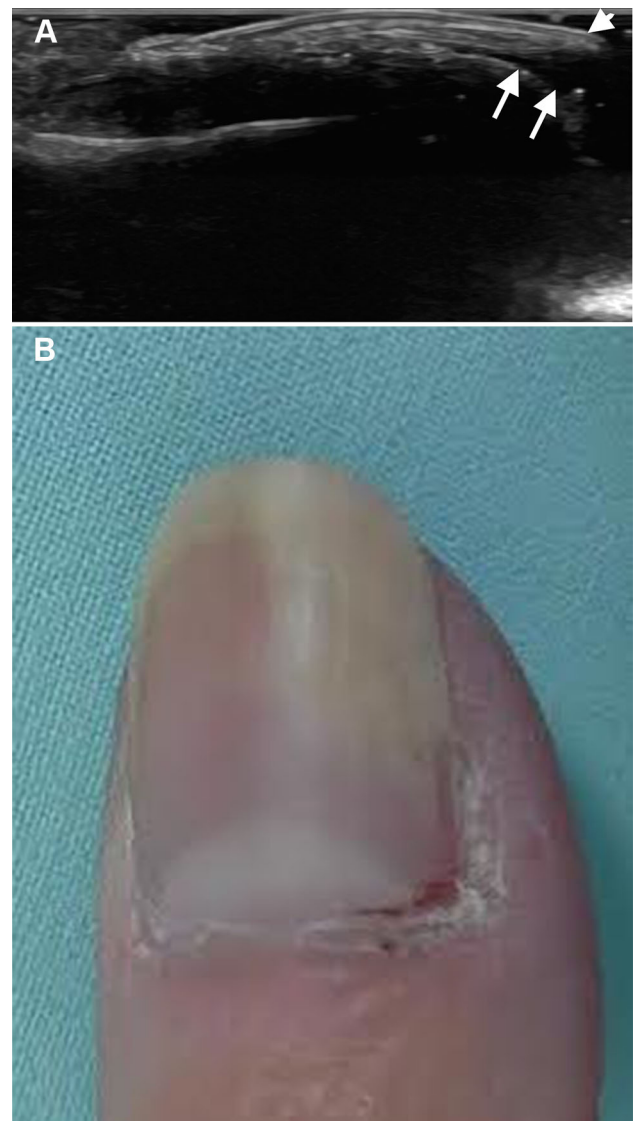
Onycholysis on patient with onychomycosis caused by *Candida*. a Ultrasound, longitudinal view. Separation of the distal edge of the nail bed affecting the medial aspect of the nail (arrows), with thickening of the nail plates (arrowhead). b Separation of the distal edge of the nail bed affecting the medial aspect of the nail (arrows)
